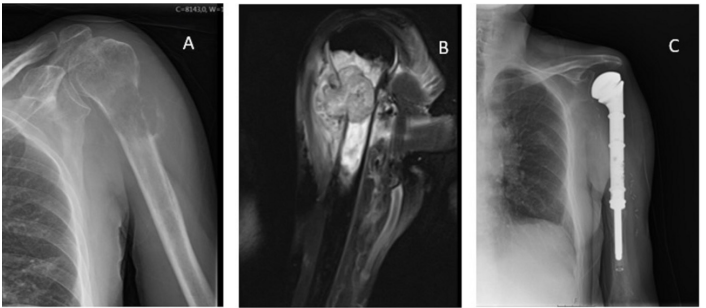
The 56-year-old man with lung carcinoma metastasis of bone showing (A) anterior-posterior and radiograph of the humerus showing a lytic lesion of the proximal third of the shaft. (B) MRI sagittal sequences show extensive destruction of the anterior and lateral cortex with associated soft-tissue mass. A 13 cm segment of bone was resected and reconstructed limb with the cemented endoprosthesis implant, shown on (C) the anterior-posterior radiographs.
